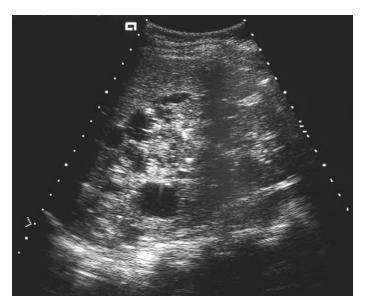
Sonogram of a 17-year-old patient with autosomal dominant polycystic kidney disease. Cysts of varying sizes are located in the cortex and the medulla.
